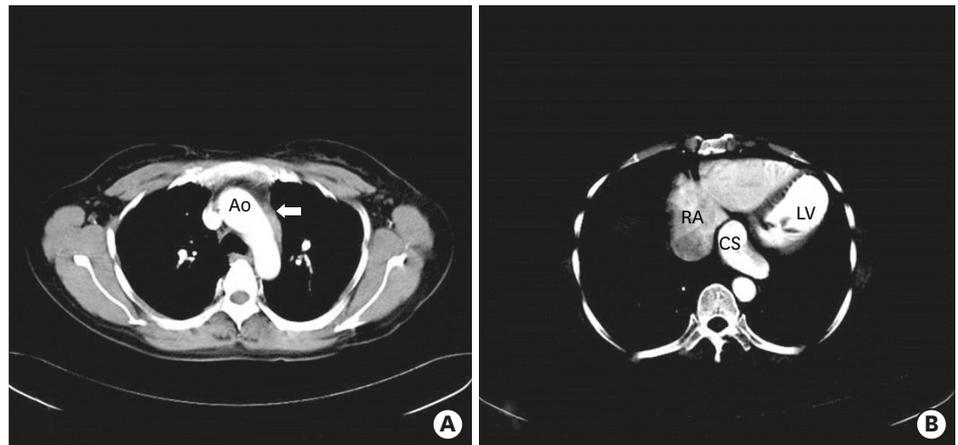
Computed tomography. (A) On computed tomography imaging, there was no persistent left superior vena cava (arrow). (B) A huge dilated CS was observed, showing no communication with the RA, which suggested CS orifice atresia. Ao: aorta, CS: coronary sinus, LV: left ventricle, RA: right atrium.
